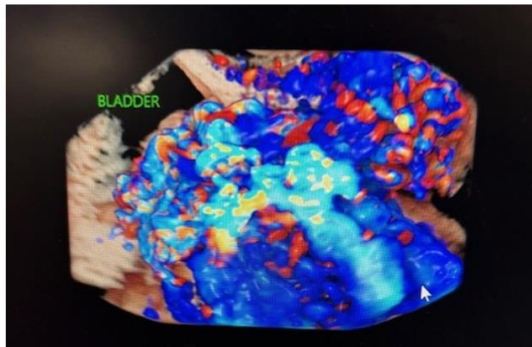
3-Dimensional ultrasound scan of Placenta Accreta Spectrum at 24 weeks 1 day. Shared with patient permission. Image courtesy of Dr. Deena Elkafrawi, MD, FACOG.
